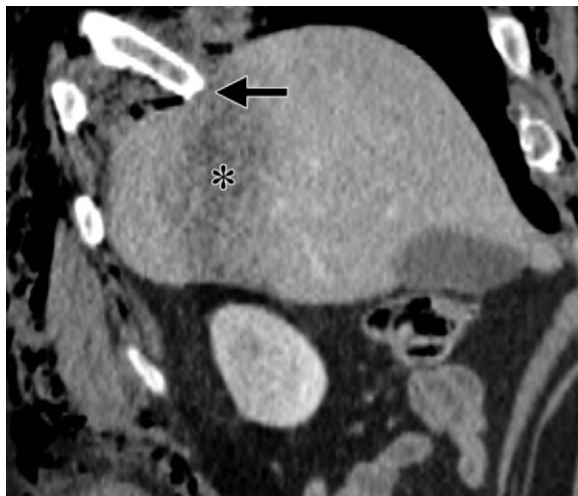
Right-sided BDR in a 56-year-old man after a motor vehicle accident. Sagittal oblique contrast-enhanced reformatted CT image shows a costal fragment (fractured rib sign) (arrow) abutting and pointing toward the deformed hepatic dome, with an associated liver contusion (*). The presence of BDR was confirmed at surgery.
